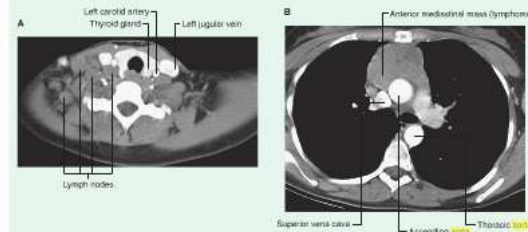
A. This computed tomogram with contrast, in the axial plane, demonstrates the normal common carotid arteries and internal jugular veins with numerous other nonenhancing nodules that represent lymph nodes in a patient with lymphoma. B. This computed tomogram with contrast, in the axial plane, demonstrates a large anterior soft-tissue mediastinal mass that represents a lymphoma.
